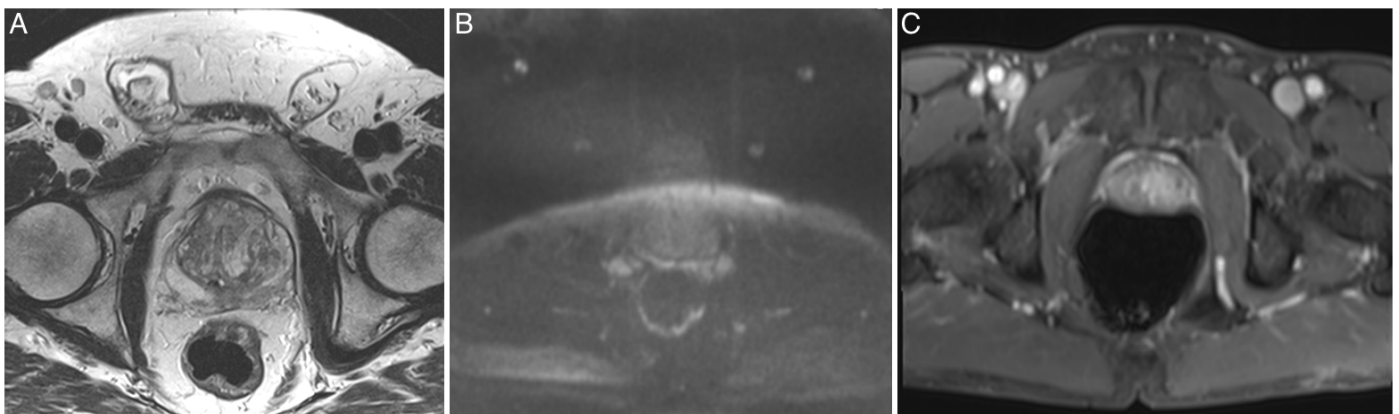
Example artefacts from low quality mpMRI (PI-QUAL 1–3) in patients with mpMRI-undetected cancer in PROMIS. (A = T2W partial motion artefacts; B = DWI artefacts; C = low in-plane resolution and distended rectum on the DCE sequence).
